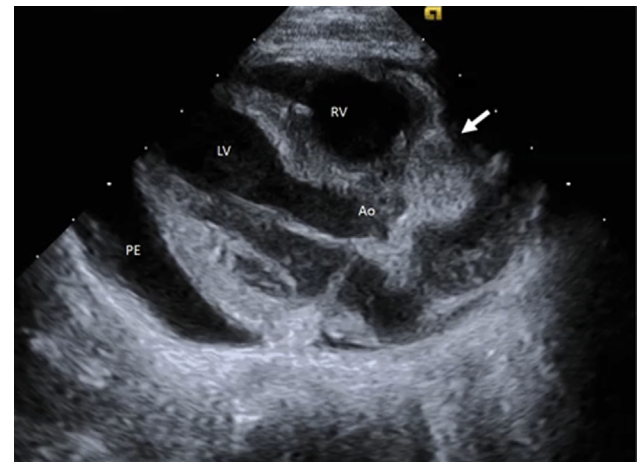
Transthoracic echocardiography from a long-axis window shows a large pericardial effusion (PE) with good left ventricular and right ventricular systolic function. A hyperechoic circular mass (*arrow*) is seen in the right AV groove anterior to the aorta (Ao). LV, Left ventricle; RV, right ventricle.
